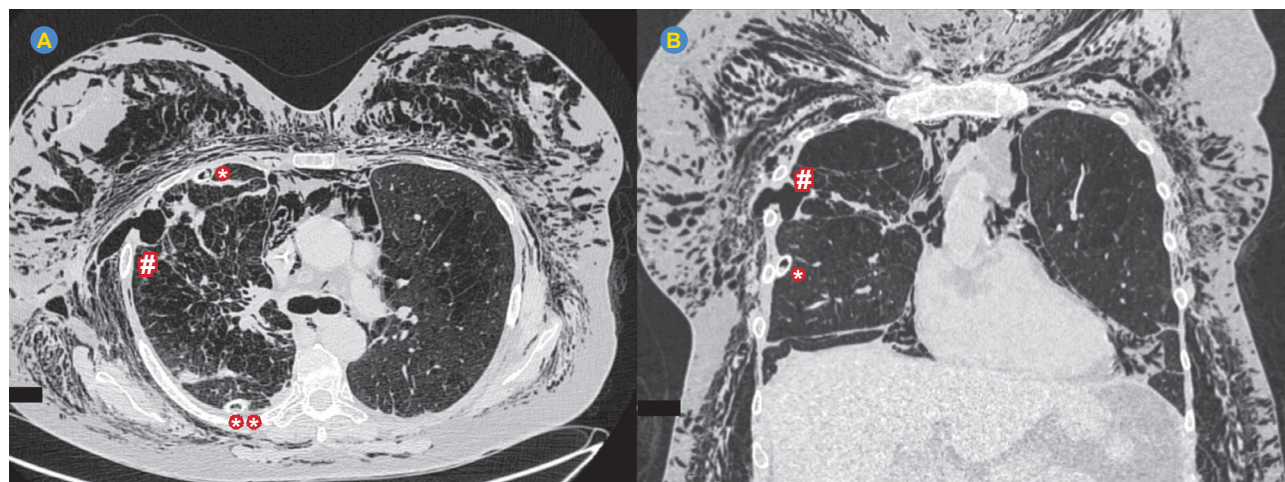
Chest CT revealing the two chest tubes placed during the first surgical intervention (* and ) as well as a fistulous tract between the lung parenchyma and the subcutaneous tissue (#)
